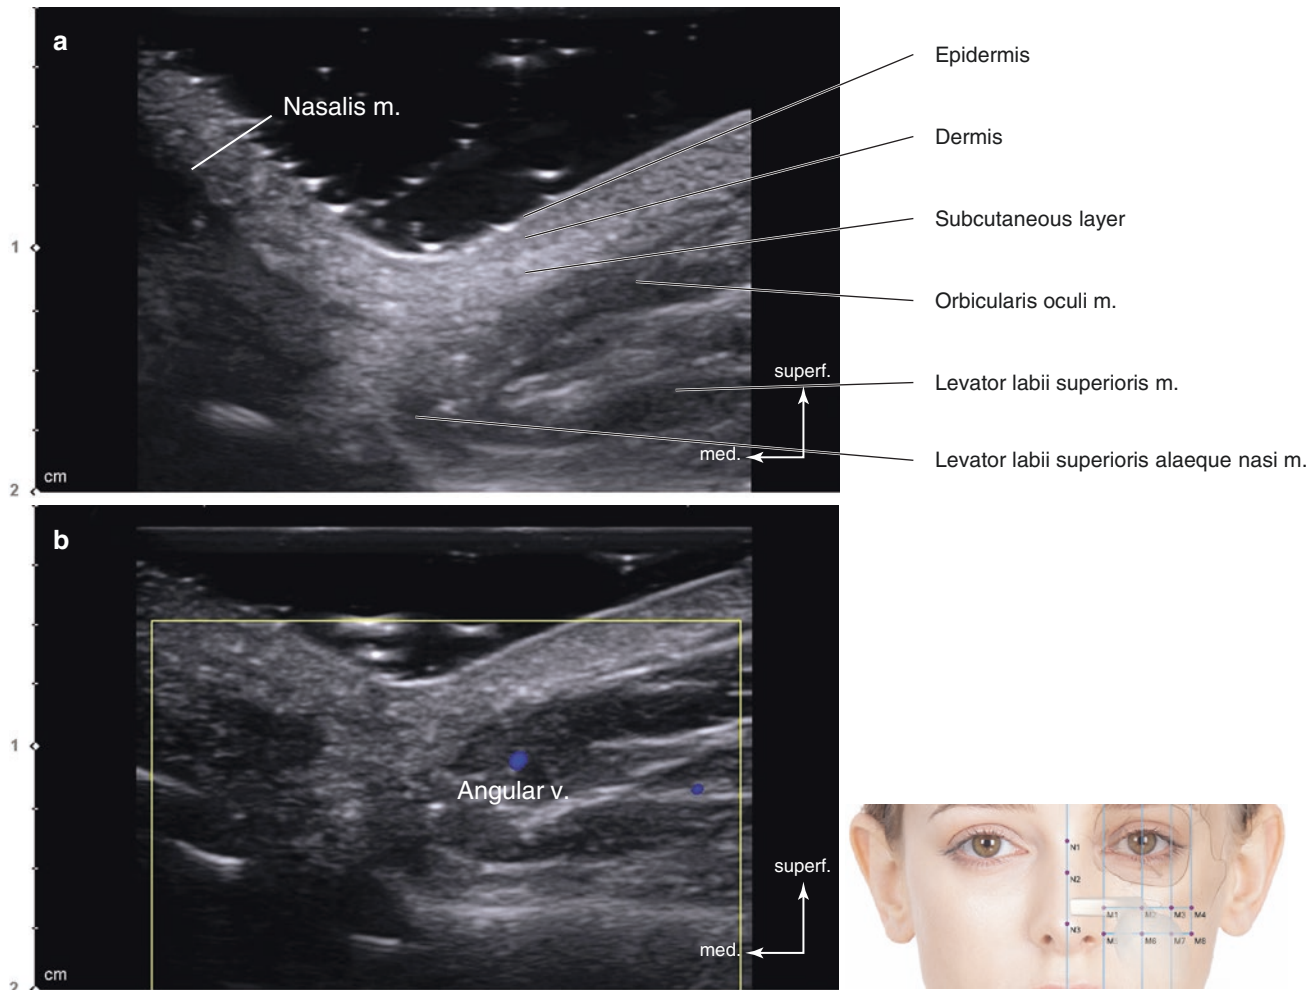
Ultrasonography on the intersection point of TL4 and PL1 (M1). (a) B mode (transverse view, 15 MHz by linear transducer), (b) Doppler mode (transverse view, 15 MHz by linear transducer), (c) B
